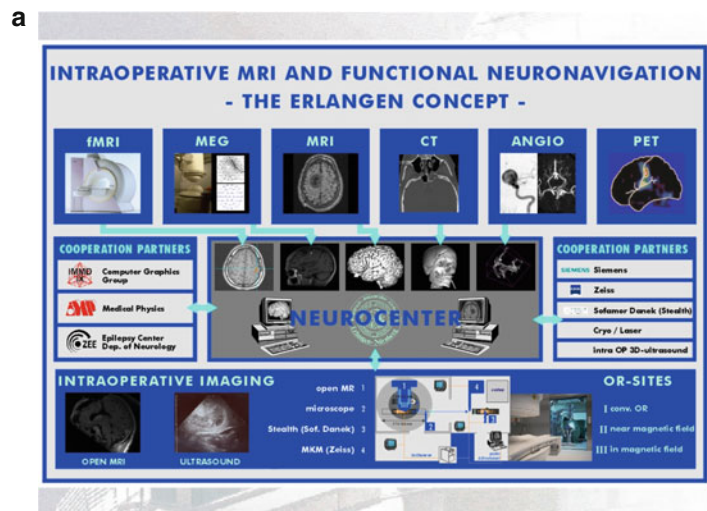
(a) Concept of the interdisciplinary Neurocenter (1996) Intraoperative MRI and functional Neuronavigation – the Erlangen Concept – to centralise neurodata for fusion, post processing and finally surgery. (b) View into the interdisciplinary Neurocenter, opened 7/2000
